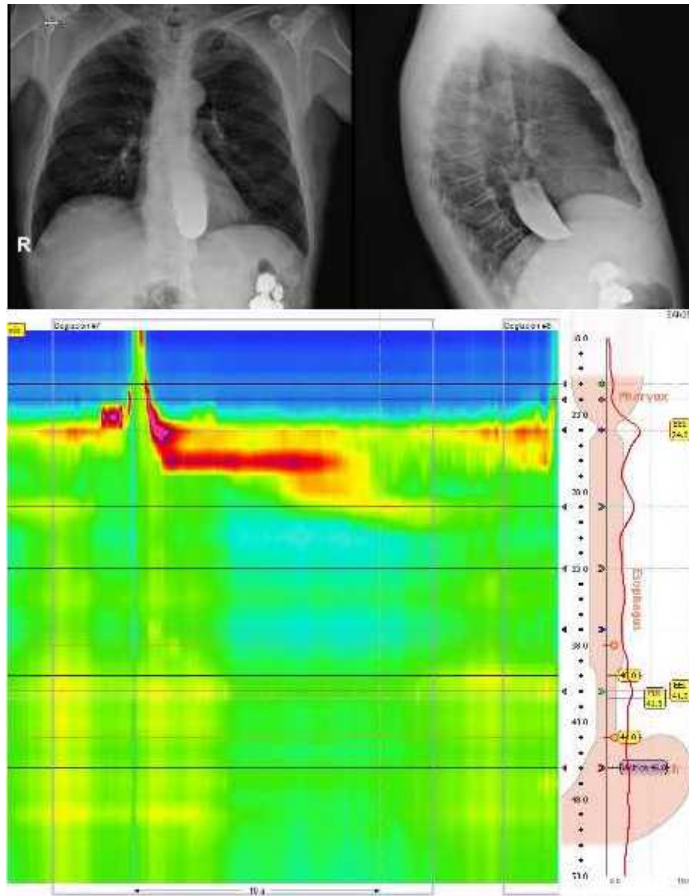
Postero-anterior and lateral chest x-rays following a gastroduodenal barium study, which showed the absence of passage through the cardia, a tapered narrowing of the distal end and proximal dilation. In the lower figure, high-resolution manometry reveals aperistaltic waves with panesophageal pressurization, consistent with type-II achalasia.
